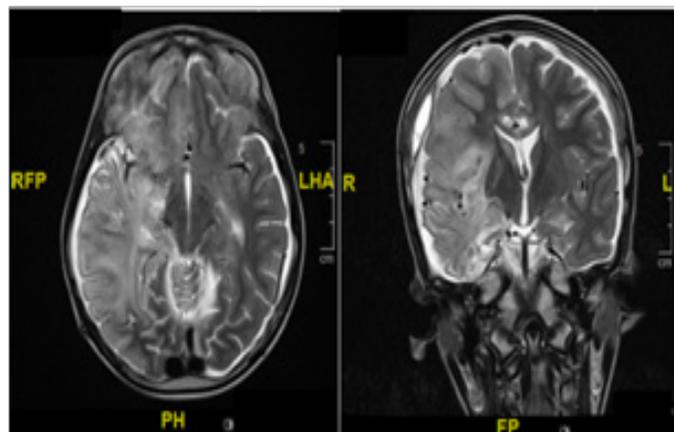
Brain MRI obtained upon symptom relapse demonstrating diffuse parenchymal edema involving most of the right cerebral hemisphere with new involvement mainly the cortex of the right frontal lobe, as well as the diffuse involvement of the right parietal and occipital lobes with persistent extensive involvement of the temporal lobe in the right side. Mild similar changes involve the left temporal lobe with new cortical edema and swelling with increase T2 signal intensity at the left peri insular gyrus. Also identified the interval development of abnormal high T2 signal intensity of the right caudate lentiform nucleus, as well as the right thalamus with newly identified diffusion restriction involving the right frontal parietal occipital lobes, as well as the right caudate lentiform nucleus and the right thalamus. Also new diffusion restriction changes seen at the left peri insular gyrus changes demonstrating loss of gray white matter differentiation. Hemorrhagic changes are also noted in the hippocampal region of the right temporal lobe.
